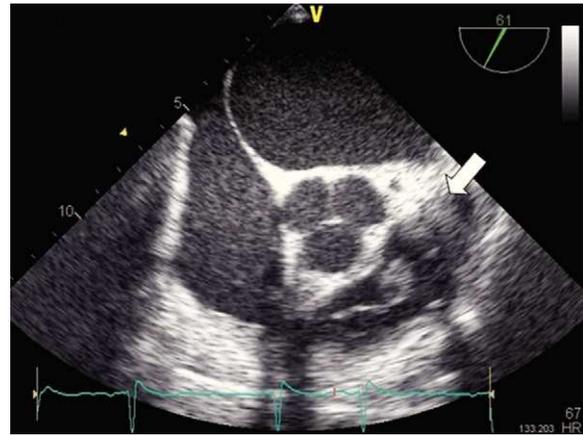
Transesophageal 61° view of aortic valve. Pulmonary valve vegetation is indicated by the white arrow.
